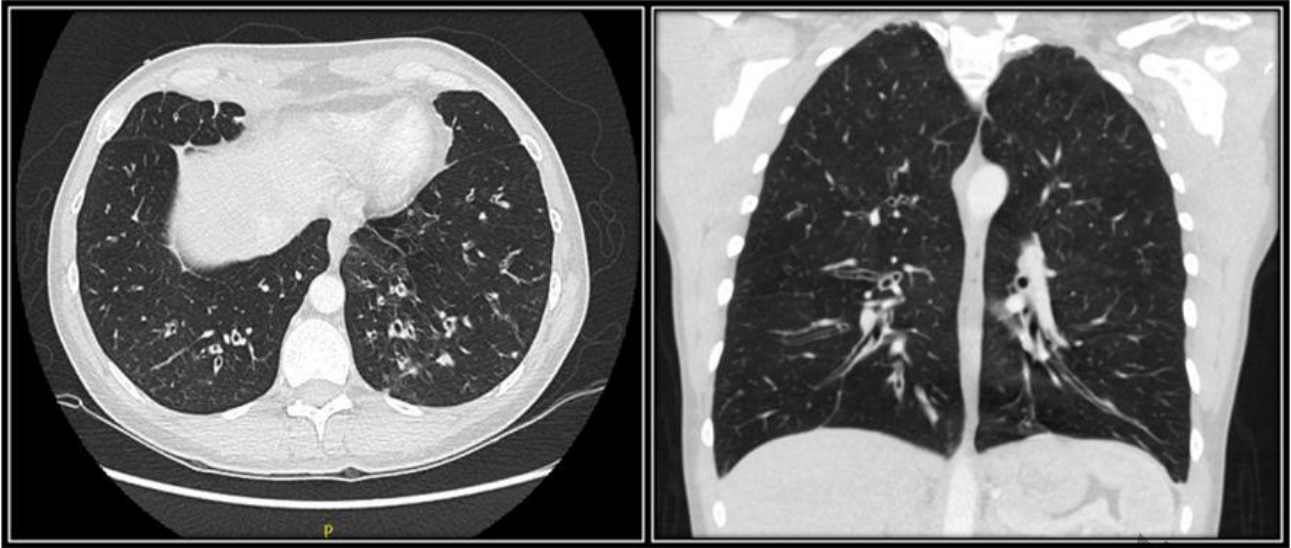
Contrast CT Thorax showing diffuse airway thickening and bronchiectasis, multiple foci of small airways mucoid impaction with distal centrilobular nodularity.
